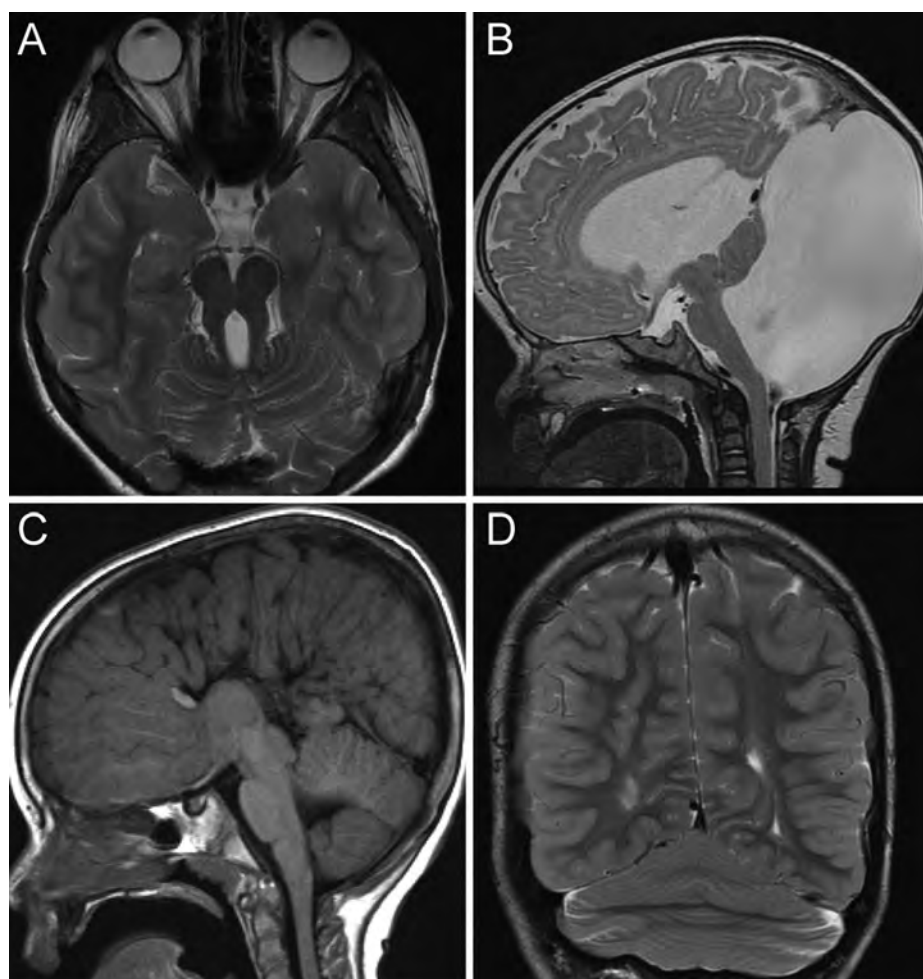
Impairments in working memory are often present in malformations involving the cerebellar vermis. (A) Joubert syndrome is a ciliopathy characterized by the “molar tooth sign” on brain magnetic resonance imaging that involves midbrain and cerebellar vermis hypoplasia or agenesis. (B) The Dandy-Walker syndrome is the most common malformation of the posterior fossa that consists of hypoplasia of the cerebellar vermis, dilatation of the fourth ventricle, and enlargement of the posterior fossa. (C) As its name suggests, hypoplasia of the inferior vermis involves partial absence of the inferior lobules of the cerebellar vermis. (D) Rhombencephalosynapsis is a rare malformation that involves fusion of both cerebellar hemispheres and dentate nuclei with absence of the midline vermis.
